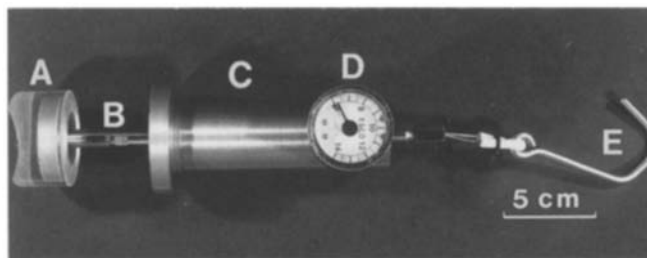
A portable stress-applying device for stress radiography. It is composed of a concave rubber pad (A), a piston rod (B), a cylinder having a spring within (C), a force gauge (D), and a hook (E) with a steel wire loop which is connected to the piston rod
